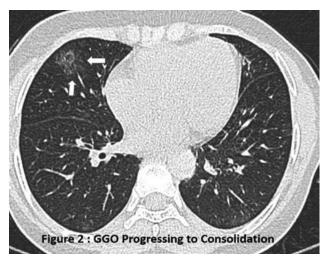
HRCT Axial image showing ground glass opacification progressing to consolidation
